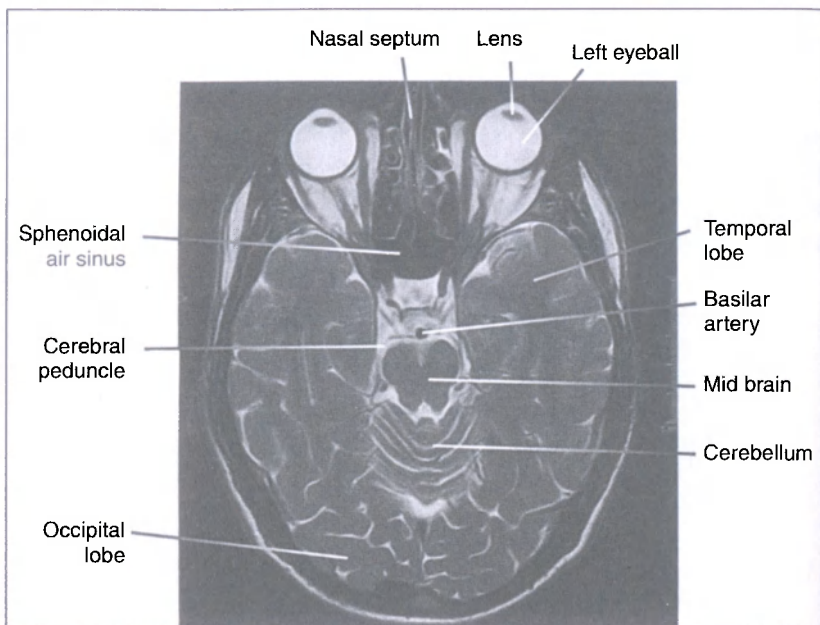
Magnetic resonance imaging of brain.
